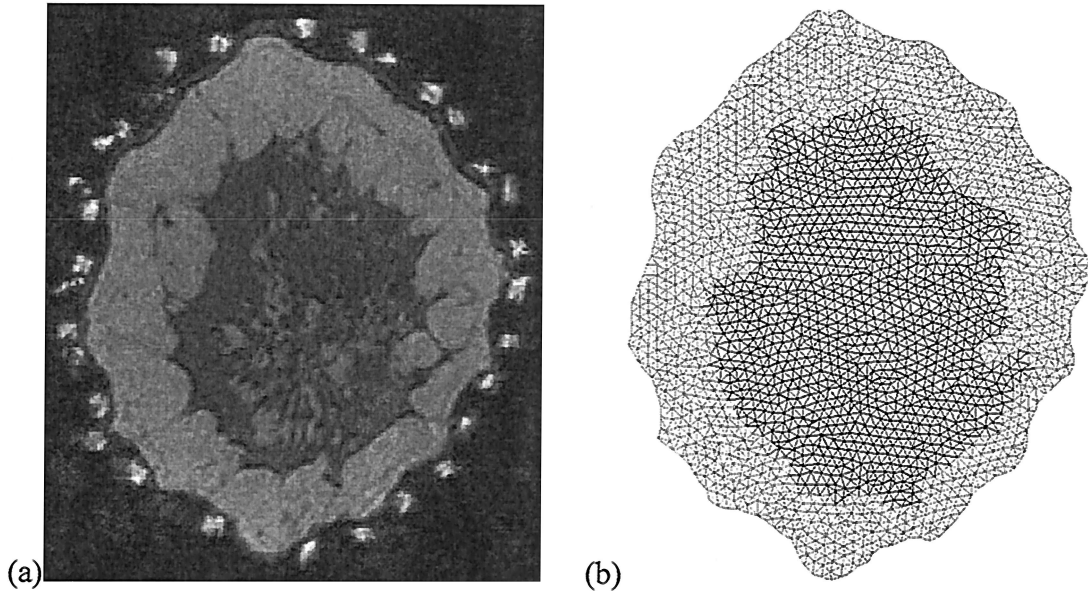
(a) Coronal slice of an MRI of a female subject showing adipose and glandular tissue layers and (b) the finite-element model mesh created from segmenting the MRI.
